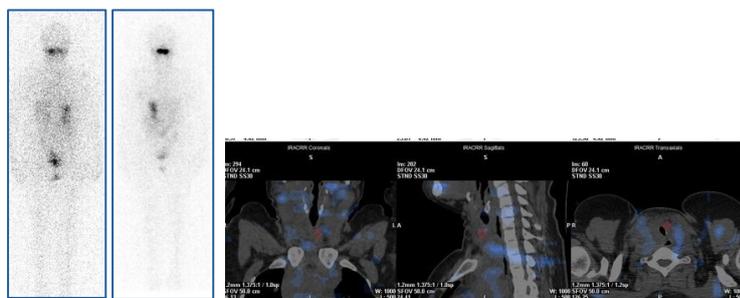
Negative WBS, no uptake in cervical and pulmonary SPECT/CT lesions
